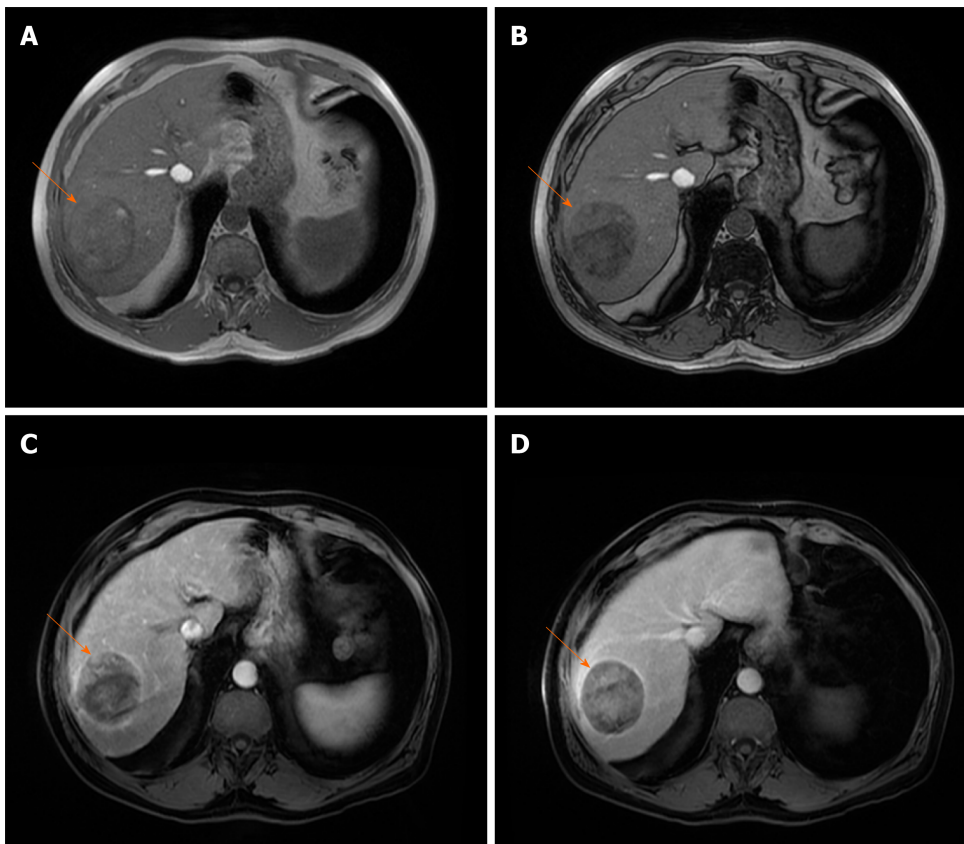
Steatotic hepatocellular carcinoma in 67-year old man with cirrhosis. A and B: T1-weighted in-phase image shows nodular tumor in segment VII (arrow) which is mostly isointense with surrounding liver parenchyma (A) with signal drop of posterior part of the lesion on opposed-phase image (B); C and D: On arterial phase image hypervascularization is clearly seen for nonsteatotic part of the tumor (C) with washout on portal-venous phase (D). Note relative lack of hypervascularity in steatotic part of the tumor, and extracapsular growth on the lateral border of the lesion.
